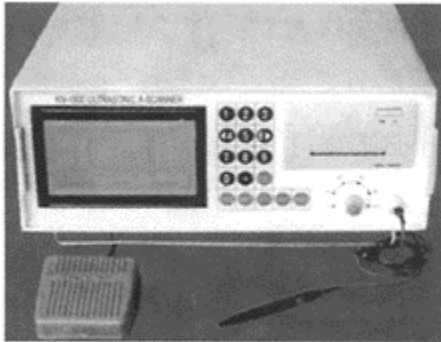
A-scan ultrasound for IOL power calculation and axial length measuring of globe
